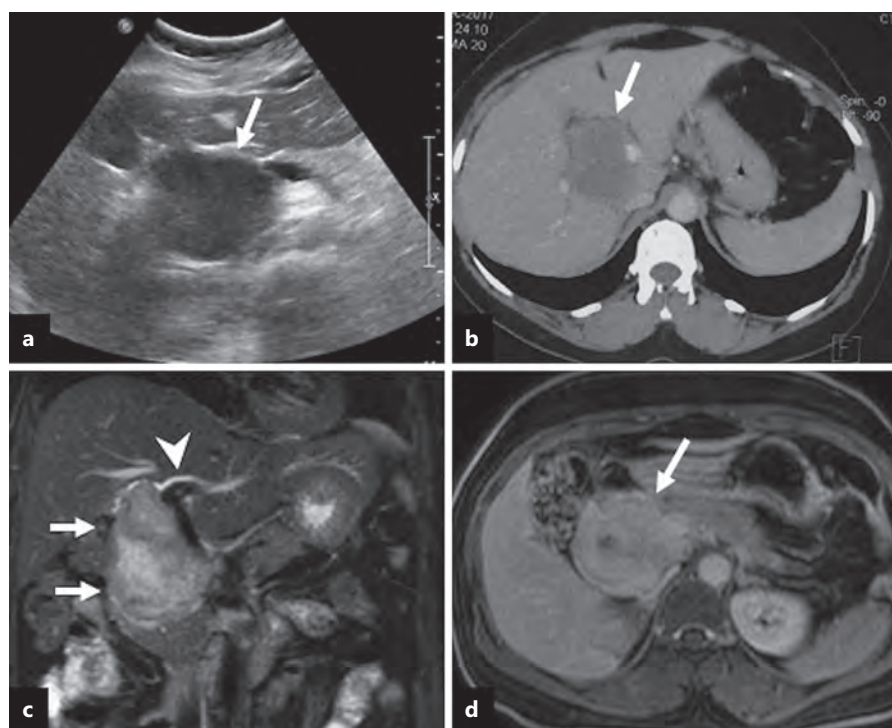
a Ultrasound image shows a hypoechoic mass (arrow) at the porta hepatis. b Axial contrast-enhanced CT image shows a hypodense mass (arrow) at the porta hepatis splaying the portal veins. c Coronal T2-weighted MR image shows an oblong hyperintense mass (arrows) along the course of the CBD with mild intrahepatic bile duct dilatation (arrow-head). d Axial contrast-enhanced T1-weighted MR image (5 min delayed) shows late enhancement of the mass (arrow).
